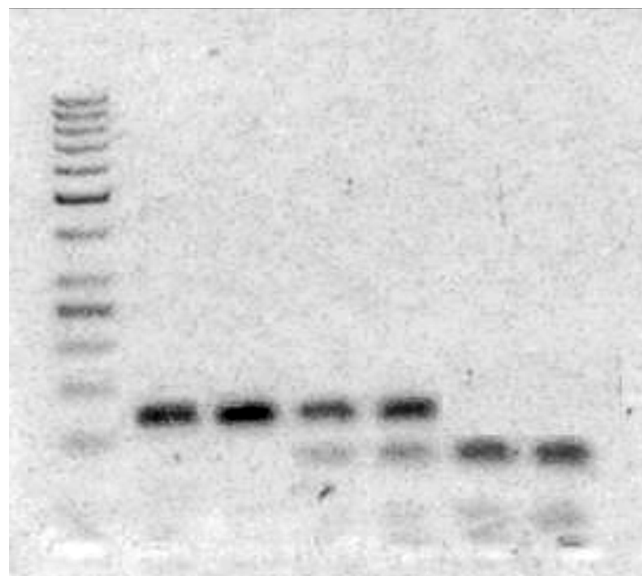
Result of agarose gel electrophoresis of DNA samples treated with *HinfI* enzyme – 677C>T MTHFR gene polymorphism. From left to right: ladder, two samples – CC homozygotes (122bp DNA fragments), two samples – CT heterozygotes (two DNA fragments: 122bp – 677C allele and two sequences of 82bp – 677T allele), two samples – TT homozygotes (DNA fragments of 82bp corresponding to 677T allele with *HinfI* restriction site).
